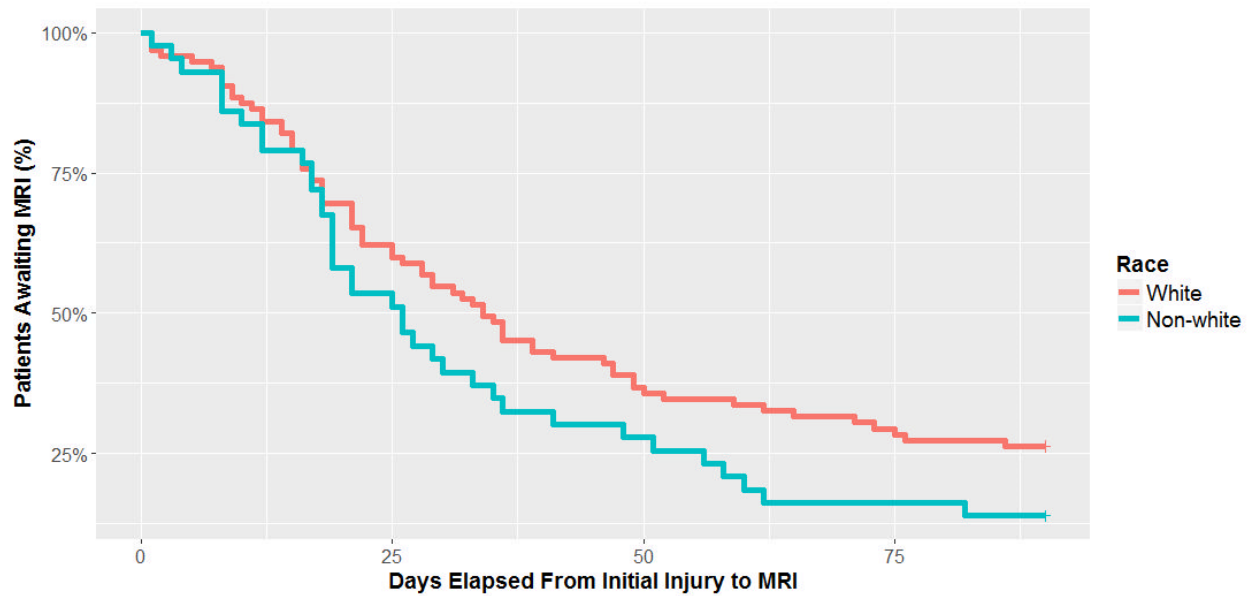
Time from Injury to MRI Stratified Based on Race
